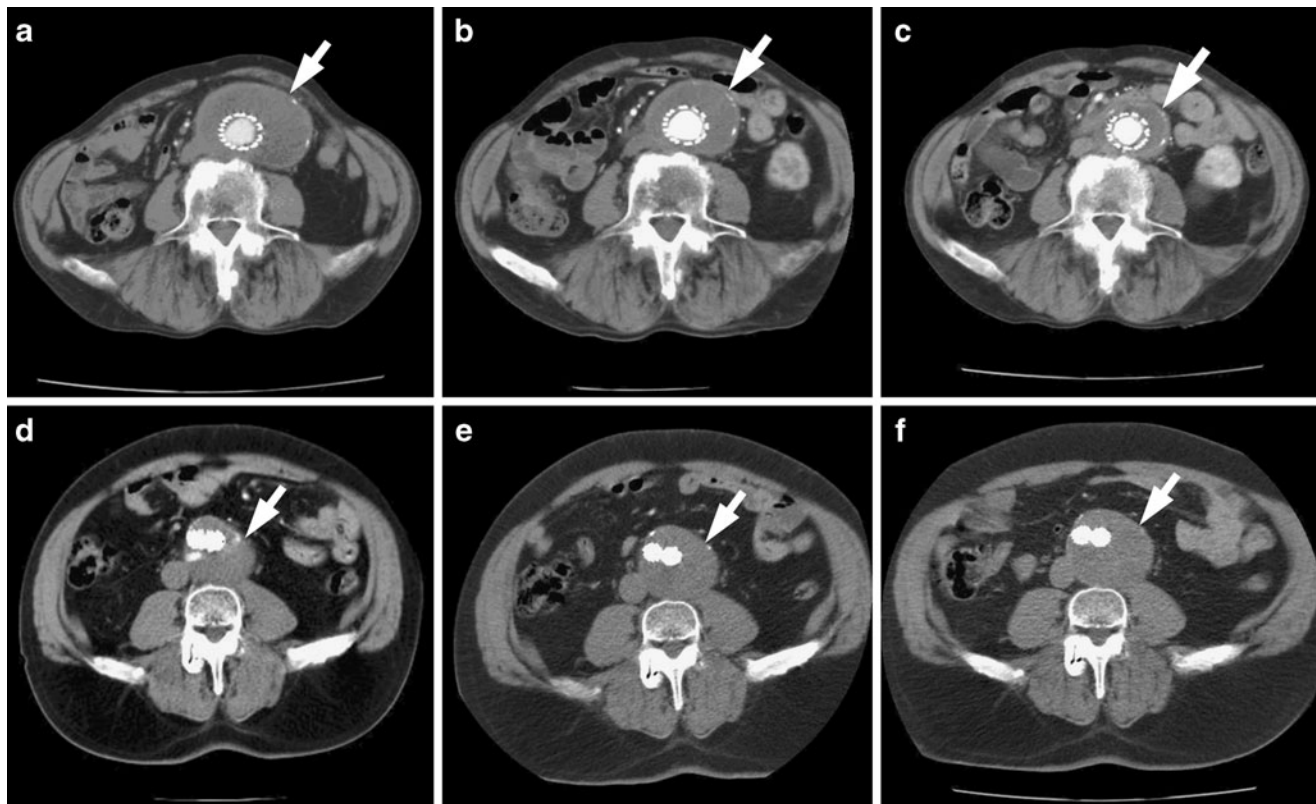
CTA images of two patients treated with EVAR. *Top row* favourable evolution—a 1 year after treatment, b 2 years after treatment, and c 3 years after treatment. *Bottom row* unfavourable
